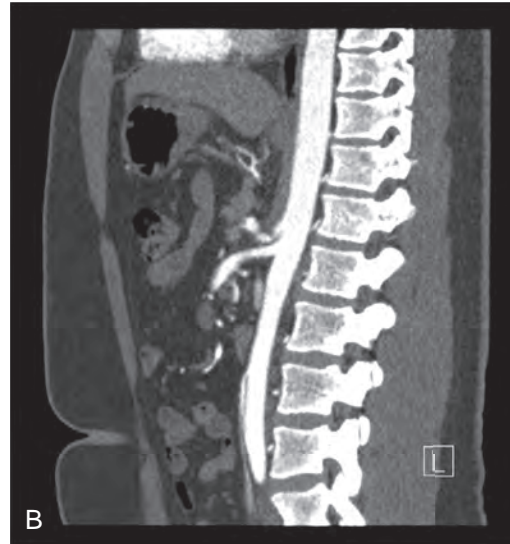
Median arcuate ligament syndrome. Expiratory (A) and inspiratory (B) contrast-enhanced sagittal CT images in a patient with median arcuate ligament syndrome. A. The expiratory image demonstrates a characteristic J-shaped indentation on the proximal celiac artery, with resultant compression. B. The degree of celiac artery compression increases on the inspiratory image.
